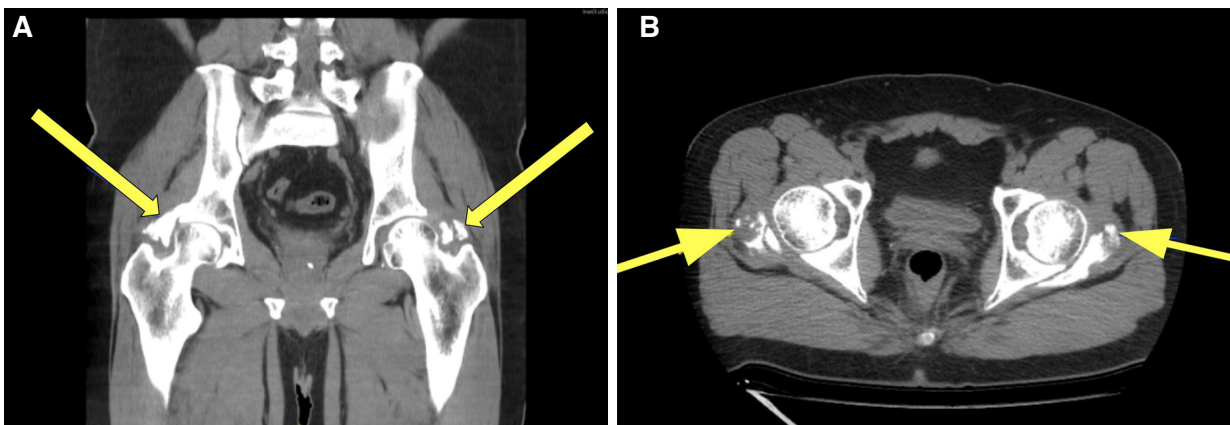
Pelvic and hip CT scan. 1A Coronal plane and 1B Axial plane. In both images, the arrows indicate the presence of heterotopic ossification.
